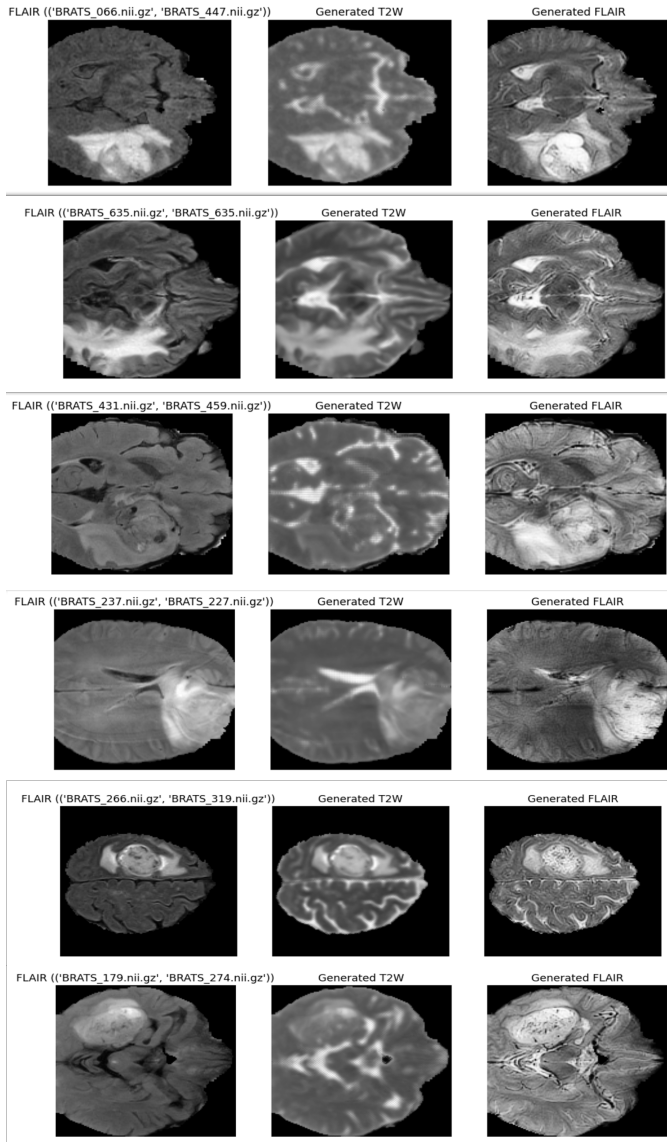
Overview of Generated synthetic Images from FLAIR to T2w
